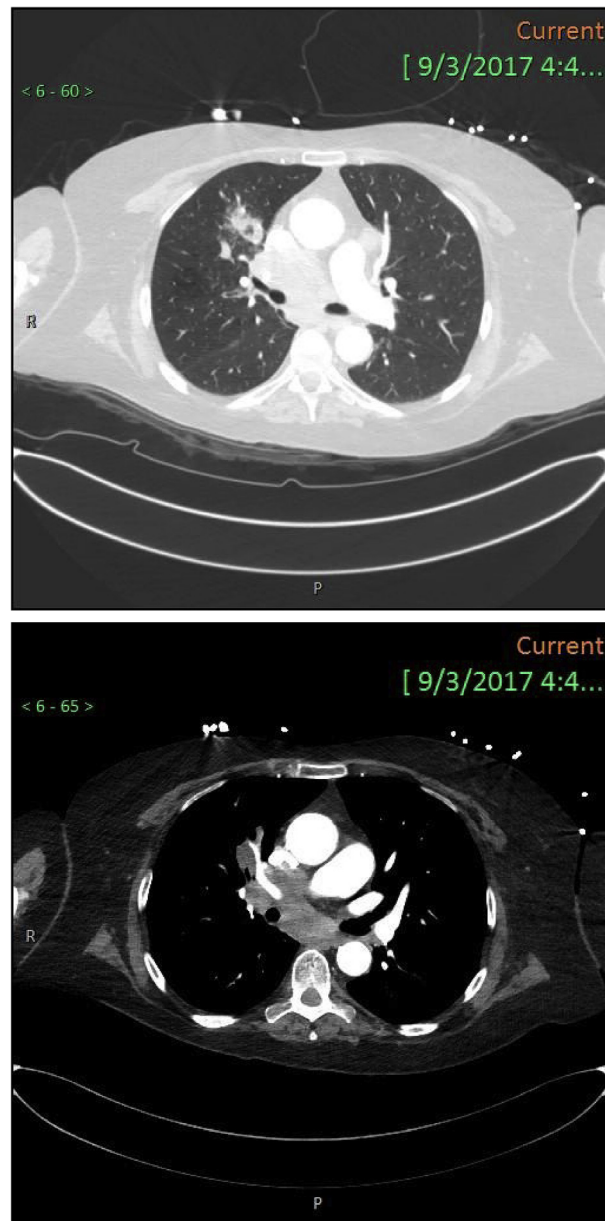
(a): Chest CT angiogram demonstrating a 3.0 × 1.5 cm mass in the anterior medial right upper lobe of the lung. (b): Chest CT angiogram demonstrating mediastinal and right hilar lymphadenopathy.
